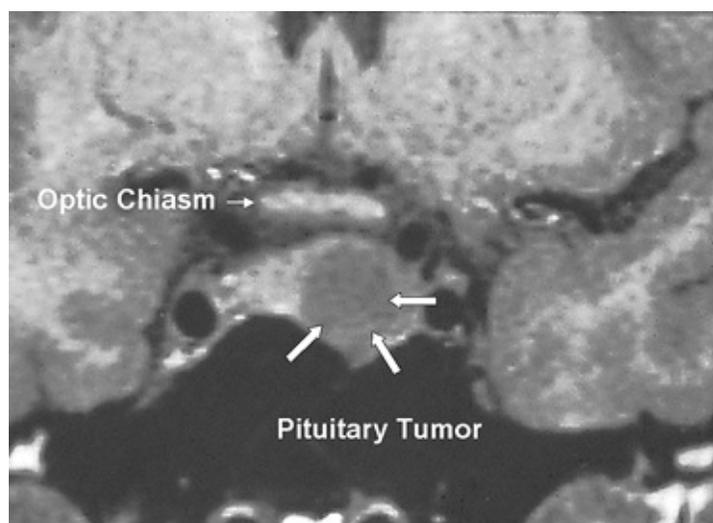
A pituitary tumor. MRI of a prolactin-secreting pituitary tumor (*three large arrows*). Note the lateral location and elevation of the diaphragm sella. However, the tumor does not compress the optic chiasm (*single arrow*), and thus no visual disturbances would be anticipated.
